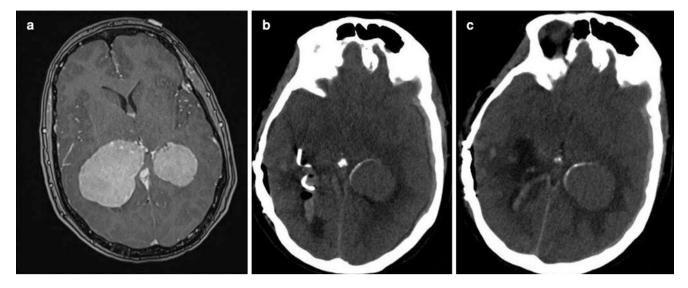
In a 35-year-old woman with meningiomatosis, surgical removal of a right trigone meningioma was complicated by retention of a cottonoid in the wound. Preoperative magnetic resonance imaging demonstrated bilateral intraventricular tumors (a). The resection of the right-side mass lesion was uncomplicated, but the absence of one cottonoid was noted at the end of the surgery, and, despite all attempts, it
